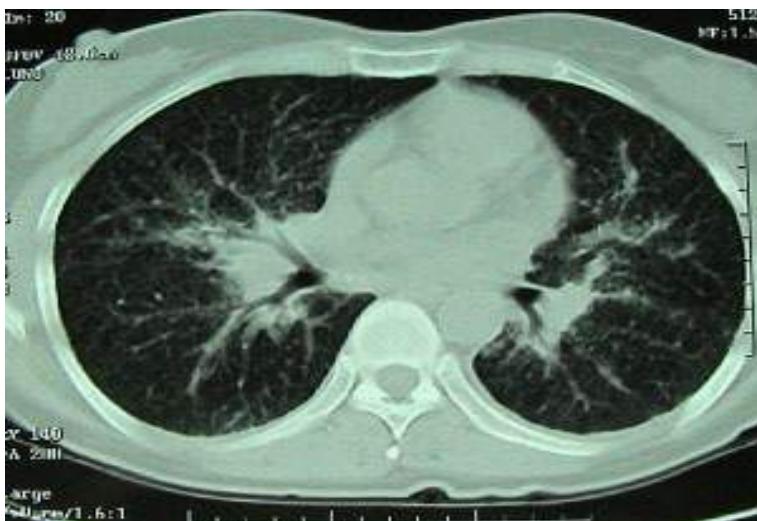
CT: Bilateral perihilar lymphadenopathy combined with pulmonary infiltration.
